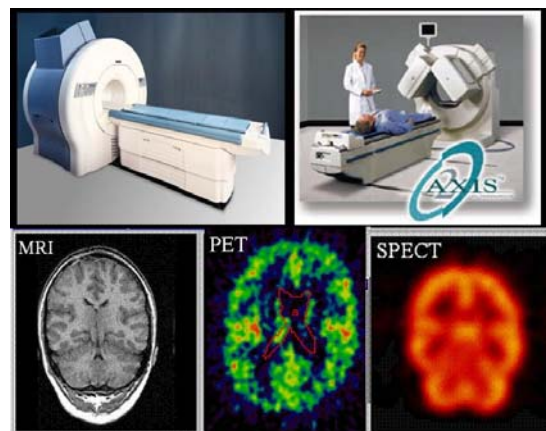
MRI and SPECT scanners and examples of cross-sectional images of brain obtained from them.
